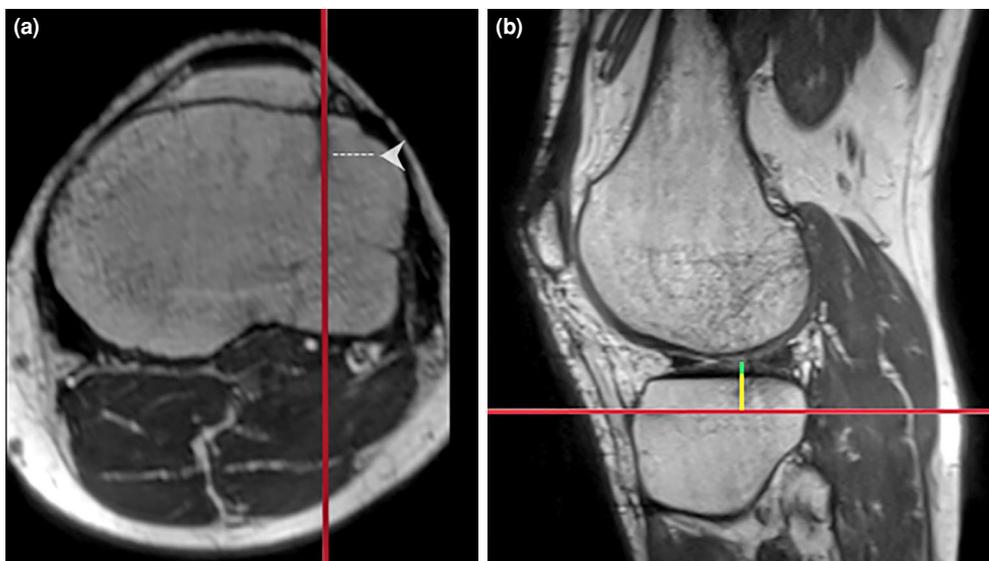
MRI examination. (a) A line (red line) parallel to the tibial plateau's least degenerated part; the line was drawn from the medial projection of the GT's upper border (arrowhead). (b) The craniocaudal (vertical) distance between red line and the cortex of the proximal lateral tibial condyle was measured (yellow line). At this level, the thickness of the lateral tibial cartilage (green line) was also measured.
